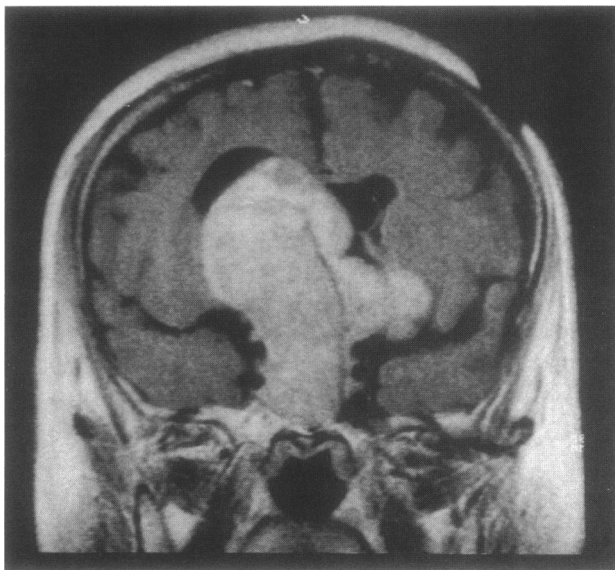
T1-weighted MRI of a giant pituitary adenoma extending above the level of the Foramen of Monro (case 4). The tumor mainly has a midline location and has not invaded the cavernous sinus.
